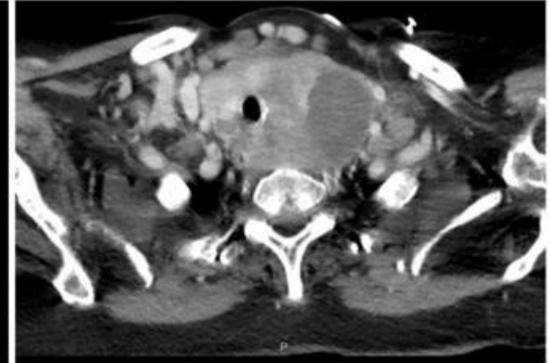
Axial contrast-enhanced CT image of a pathologically-proven thyroid carcinoma. The TG is heterogenous with local lymphadenopathy.
